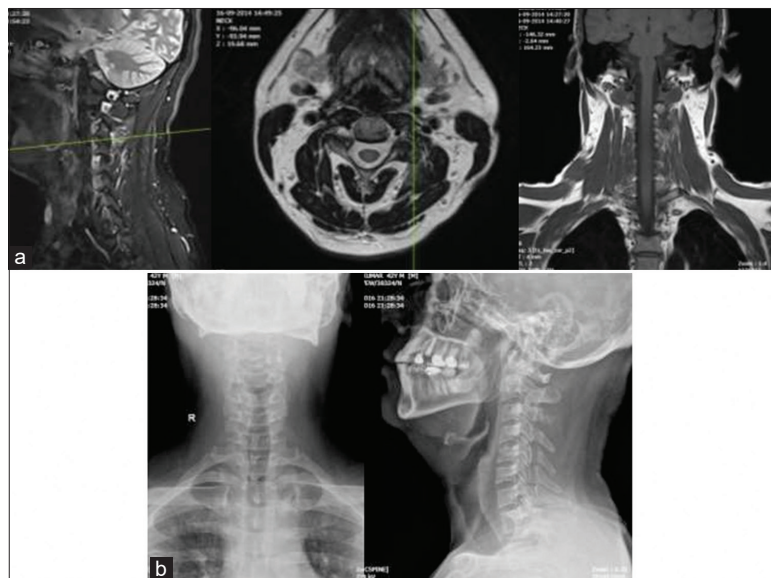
(a) MRI showing lesion involving C3 lateral mass on the left side. (b) Postoperative AP and lateral X-ray following curettage and excision without stabilization for C3 osteoid osteoma.
